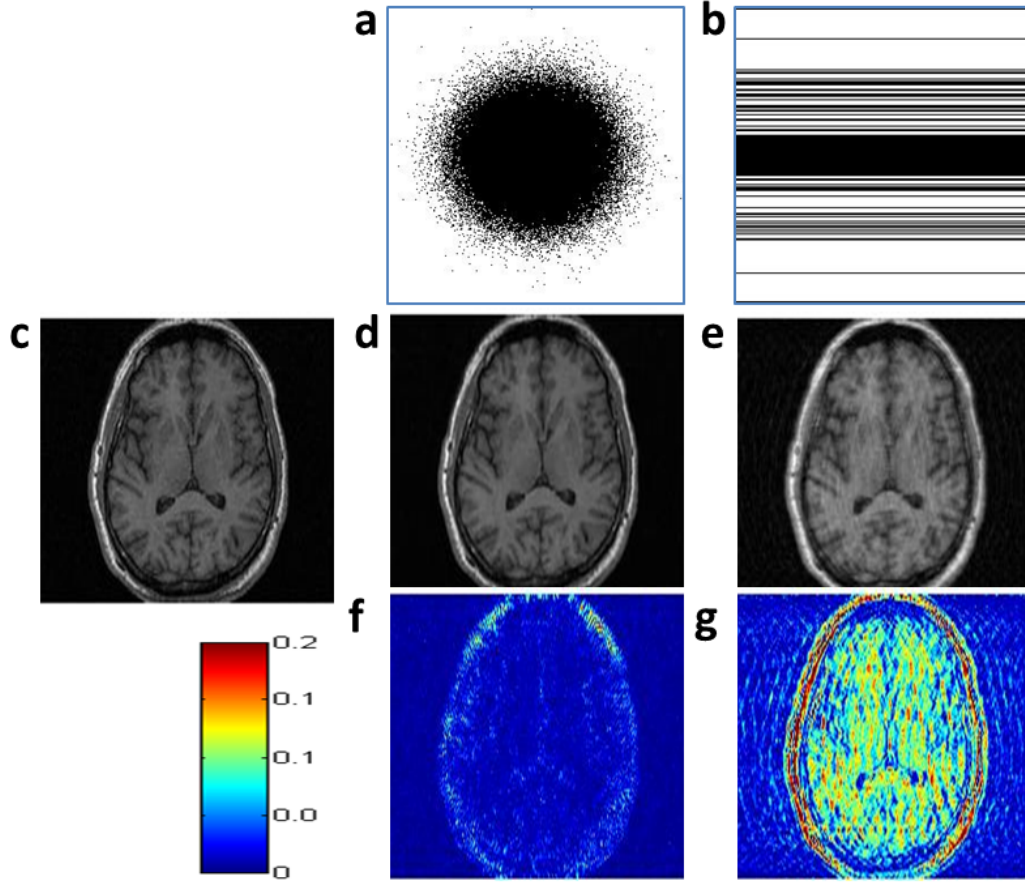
Compressed sensing of a T2-weighted brain MR image a) Gaussian distributed sample-points (black dots) in k -space, b) Variable density 2DFT under-sampling, sampled phase encode lines are shown as black-lines, c) Reference image, d) CS-MRI recovered image using samples from a, and e) recovered image using samples from b, f) & g) recovery error maps for Gaussian and Cartesian under-sampled images.
